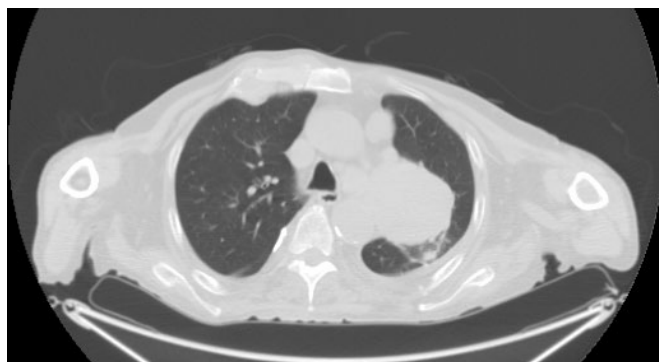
Thorax CT cross-section
